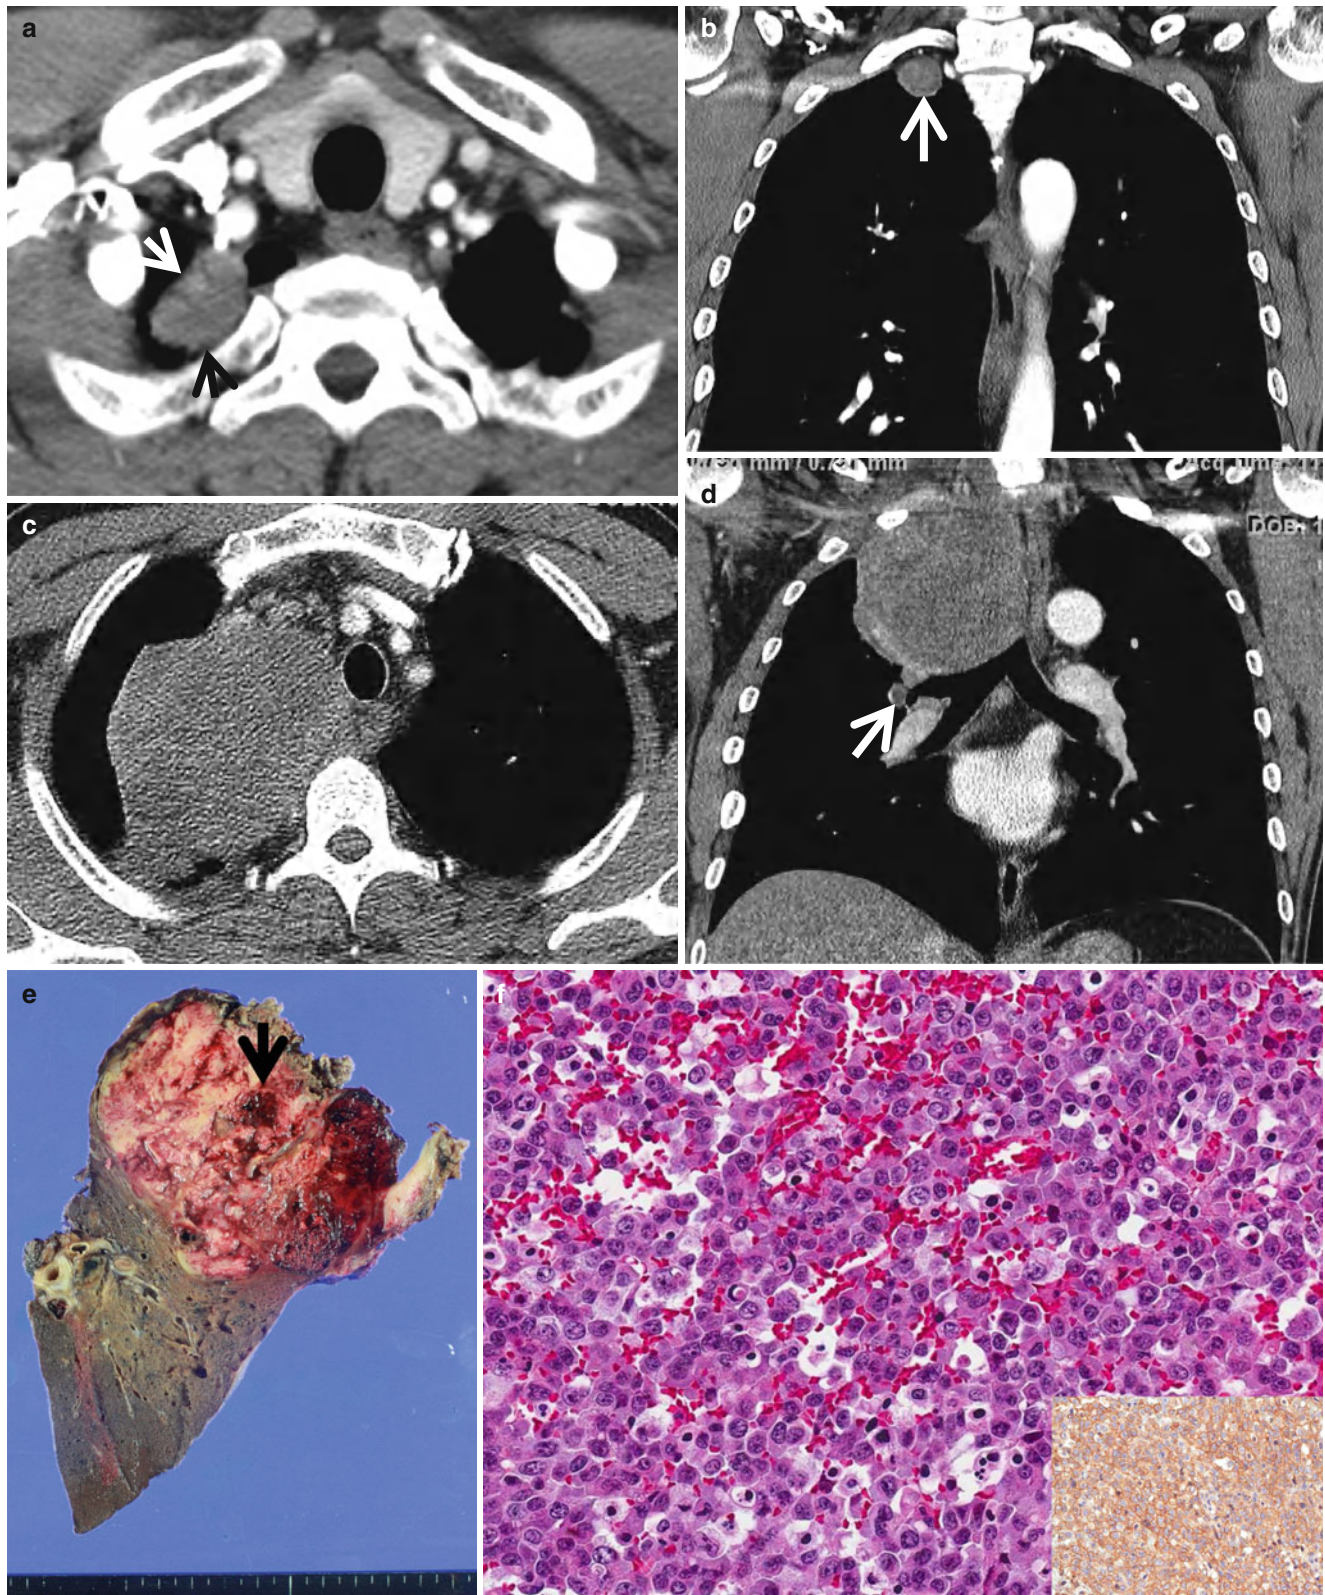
Lung mass proved to be an undifferentiated pulmonary sarcoma in a 49-year-old man. (a, b) Mediastinal window of transverse (a) and coronal (b) reformatted images of CT scans shows a 28-mm-sized nodule (arrows in a and b) in right apical area. Initially nodule was interpreted as a neurogenic tumor. (c, d) CT scans obtained 7 months after a and b demonstrate markedly enlarged mass measuring 90 mm in diameter
